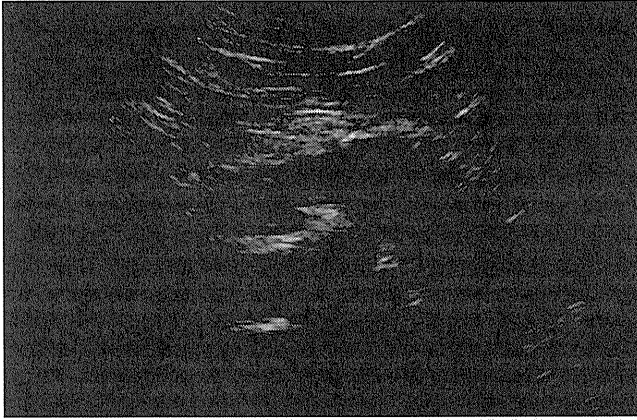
Abdominal ultrasonography (US) of a patient with autoimmune pancreatitis. Sonoluent swelling is observed in the body and tail of the pancreas.
